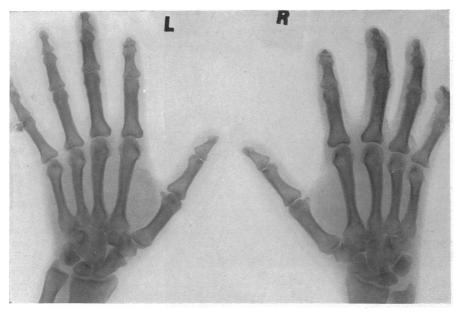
An X-ray of patient's hands showing the flattening of the terminal phalanges of index and middle fingers.
